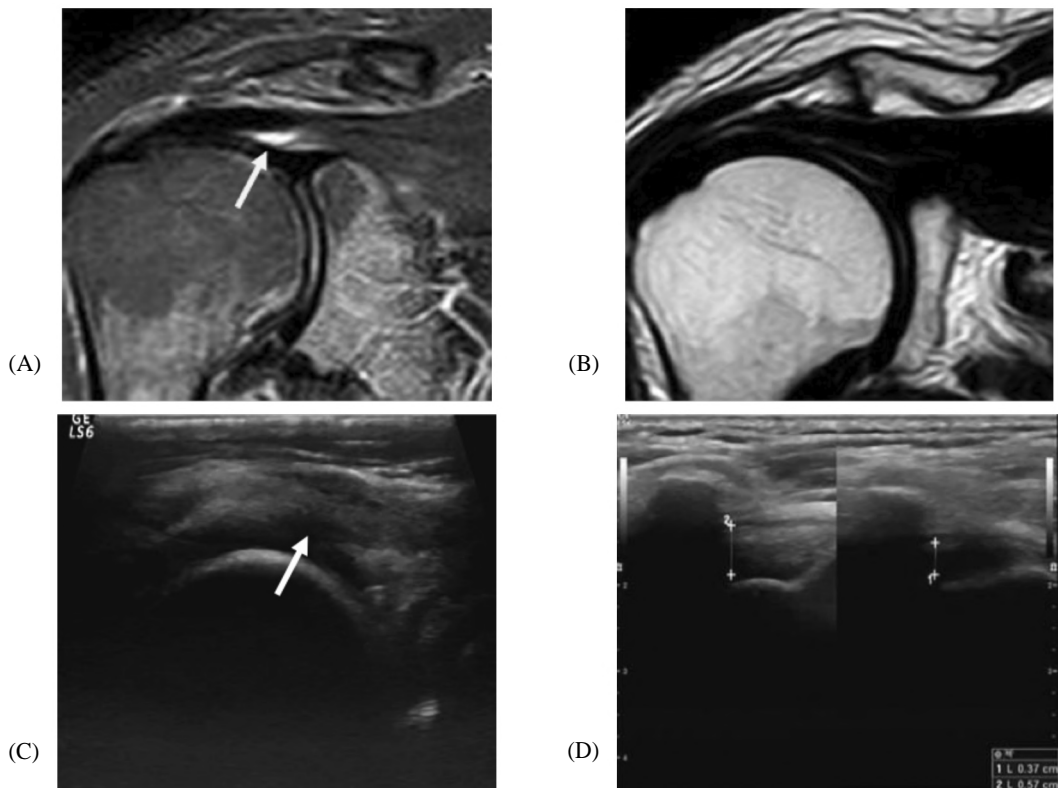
(A): MRI, sagittal STIR WIs: fluid signal seen at the articular surface of the musculo-tendinous junction of supraspinatus tendon "arrow". No evidence complete fiber interruption detected. (B) MRI, Coronal T2WIs of the shoulder showing acromio-clavicular osteoarthritis. (C) Static US images shows partial thickness tear of the humeral surface of the supraspinatus tendon, seen as a hypoechoic linear defect interrupting the tendon fibers "arrow". (D) Dynamic ultrasonography showed narrowing of the sub acromial tunnel that became accentuated in stress position.
